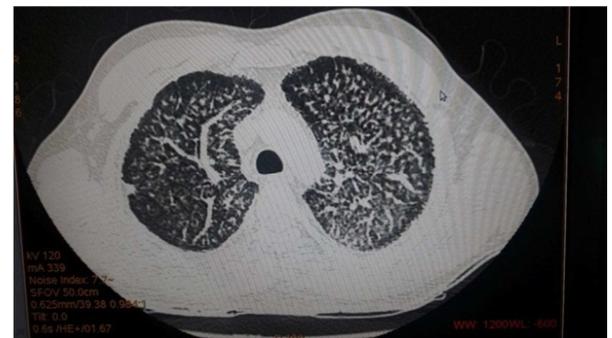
CT scan shows diffuse distribution of micronodular calcific densities in the subpleural parenchyma and along the broncho-vascular bundles. black pleura sign.
